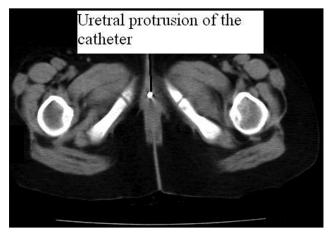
Abdominal CT shows an abdominal catheter protruding from urethra
